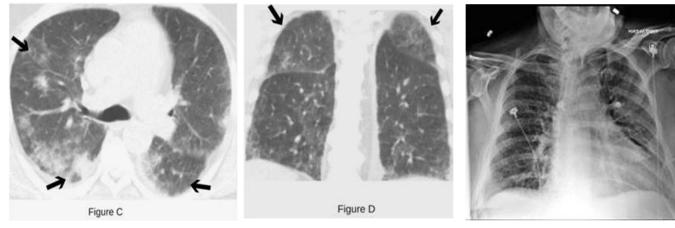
Figure C&D: Chest computed tomography scan revealing bilateral upper lobe ground glass opacities (*arrow heads*) and mild to moderate interstitial fibrosis.
